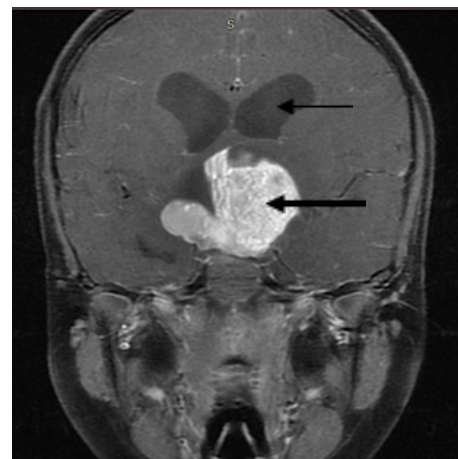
Post contrast MRI image shows intense enhancement of the solid component of the suprasellar mass (thick arrow) with bilateral hydrocephalus (thin arrow)
